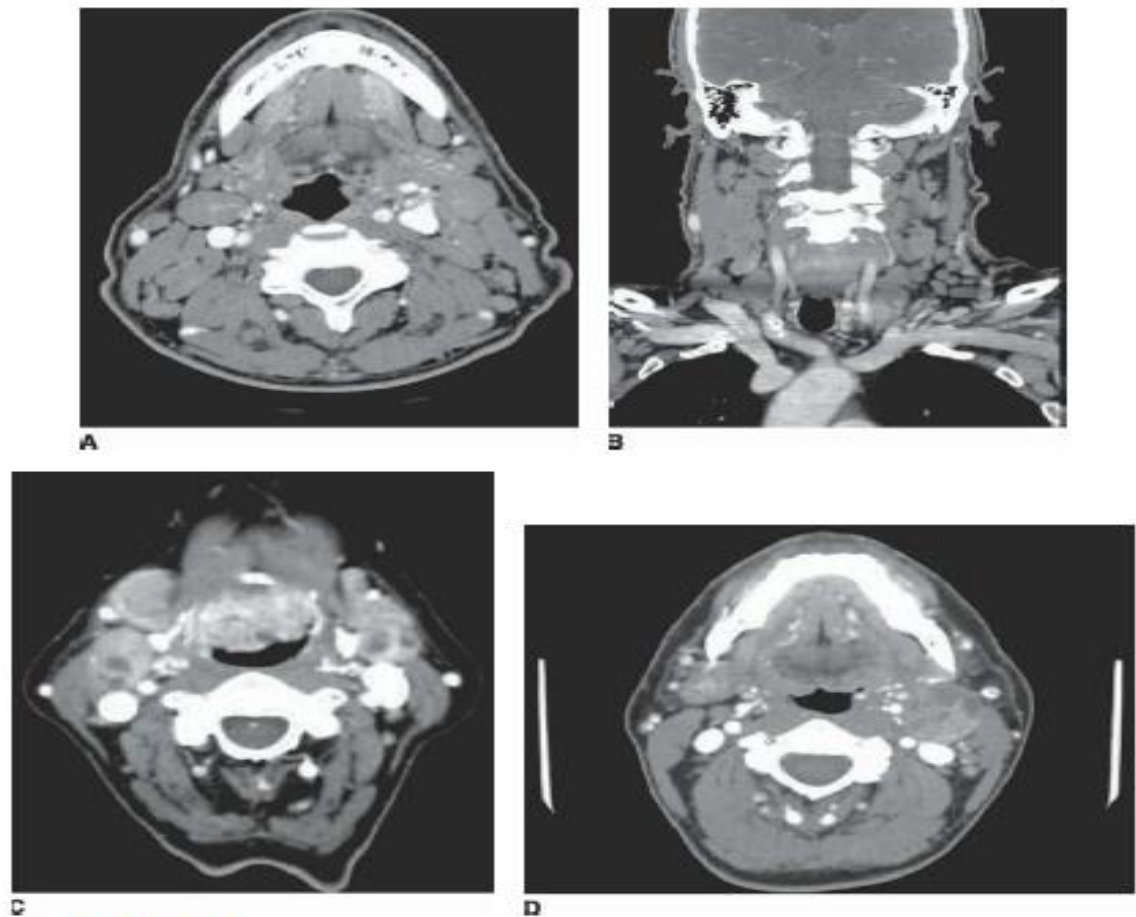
Contrast-enhanced (A) axial and (B) coronal CT images from patient with B-cell lymphoma, demonstrating multiple enlarged lymph nodes with poor contrast enhancement and uniform appearance. In contrast, lymph nodes with metastatic SCC demonstrate (C) heterogeneous enhancement as well as (D) central necrosis.
